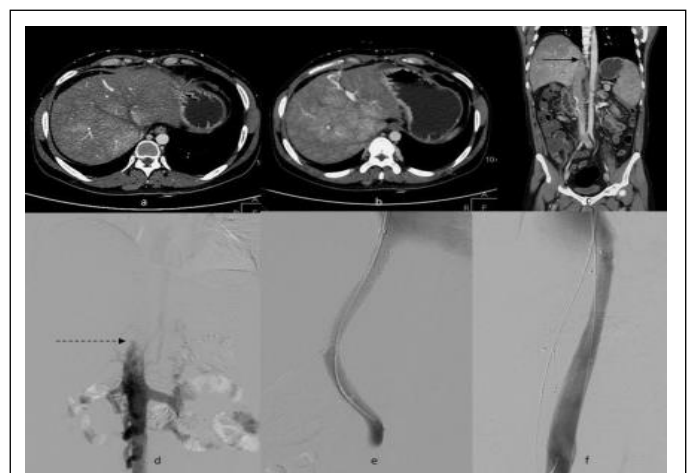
a. Axial CT abdomen section (venous phase) at level of hepatic vein ostia suggestive of non-opacification of all hepatic veins. b. Axial CT abdomen section at another level suggestive of heterogeneous enhancement of hepatic parenchyma suggestive of congestion with subcapsular collateral from left branch of portal vein. c. Coronal reformat CT abdomen image (venous phase) suggestive of occlusion of retro-hepatic inferior vena cava (arrow). d. Inferior vena cavogram confirmatory of the occlusion (broken arrow). e. After insertion of trans-jugular intrahepatic porto-systemic shunt across portal vein and inferior vena cava, portal venogram suggestive of normal flow across the shunt into the supra-hepatic inferior vena cava and right atrium. f. Inferior hepatic venogram after subsequent placement of inferior vena cava stent suggestive of normal opacification of stent lumen with flow of contrast into the right atrium and no residual stenosis/narrowing
